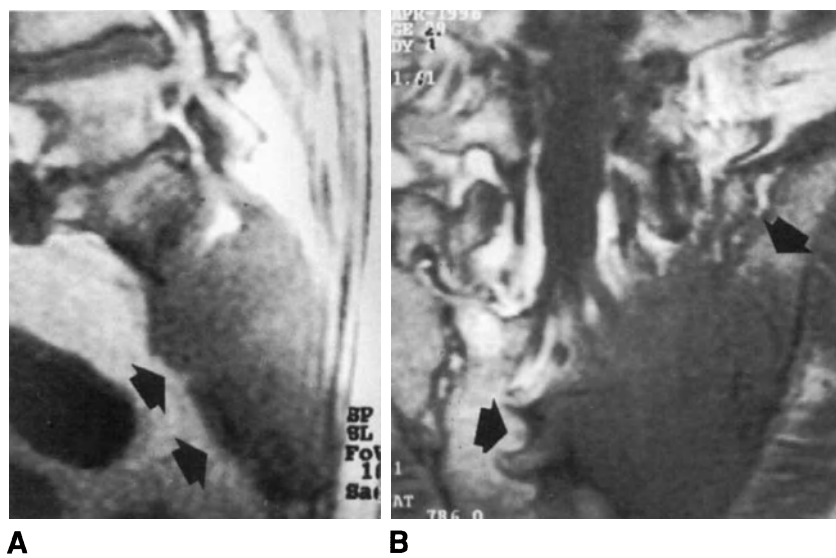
Sagittal (A) and coronal (B) T1-weighted spin-echo MR images showing a voluminous lesion with low signal intensity, located in the left half of the sacrum and extending to the adjacent portion of the ilium. The low signal intensity and the widespread bone destruction indicate a metastatic lesion.
